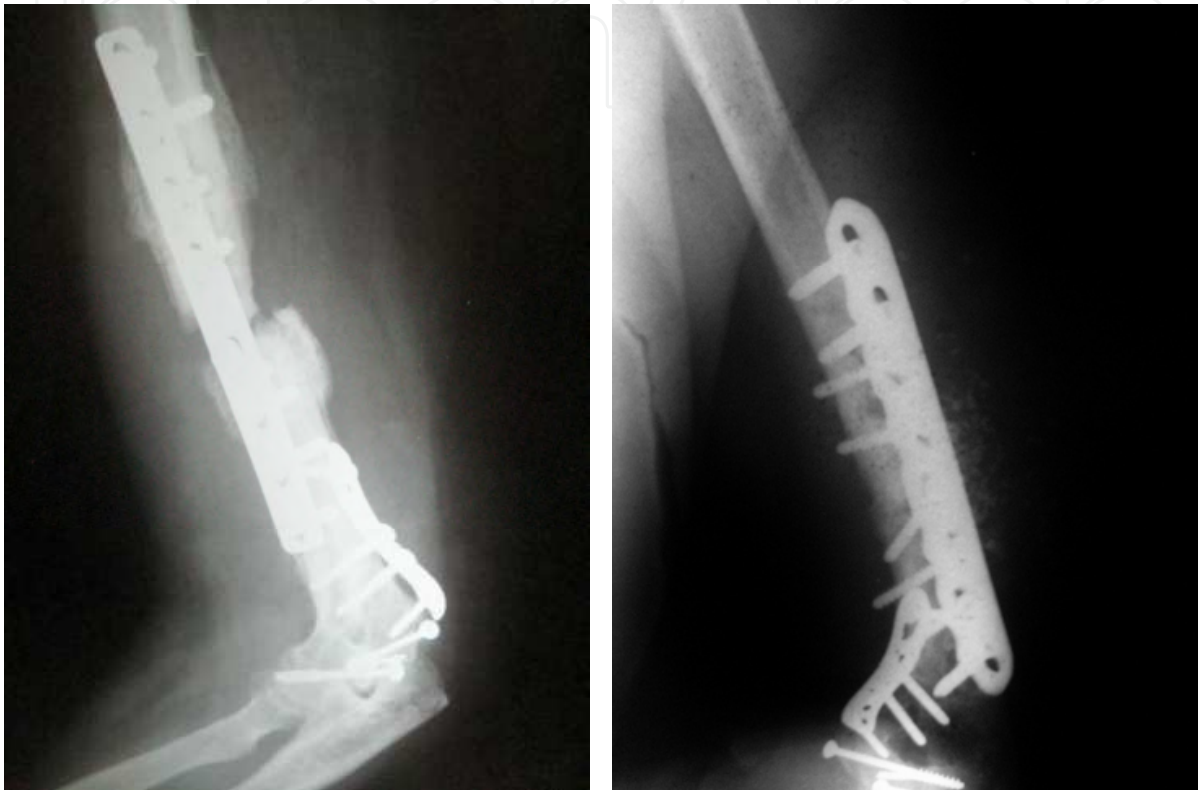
Radiograph of a malunited fracture (left) of the humerus, treated with a new synthesis material and with synthetic bone grafting
